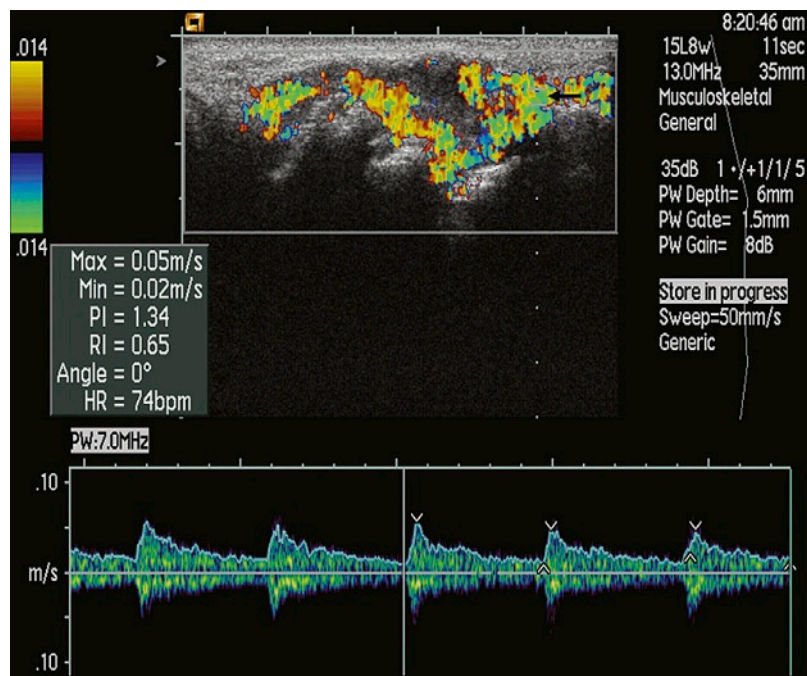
LONGITUDINAL IMAGE OF THE WRIST. Color Doppler (*top*) and spectral Doppler (*bottom*) were used to examine the wrist. Color Doppler displays areas of hyperemia in the synovium, which appears hypoechoic in areas without vascular activity. The Doppler gate (*arrow*) is placed over an intrasynovial artery, and the spectral Doppler information is displayed below. The Doppler spectrum is seen on both sides of the baseline, which happens when the insonation angle is close to 90 degrees and the system has been set for analysis over the baseline. The auto-Doppler function has traced the maximum velocities and has identified the maximum systolic velocity (V) and end-diastolic velocity (A) over three cardiac cycles. The resulting resistive index (RI) is seen in the data box.
